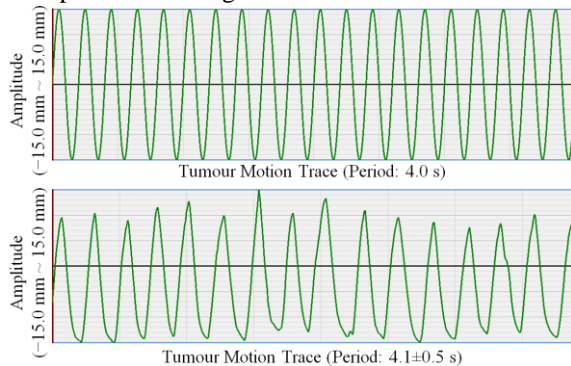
Tumour motions used during MRI scans. A sine wave (top) and lung tumour motion (bottom)
